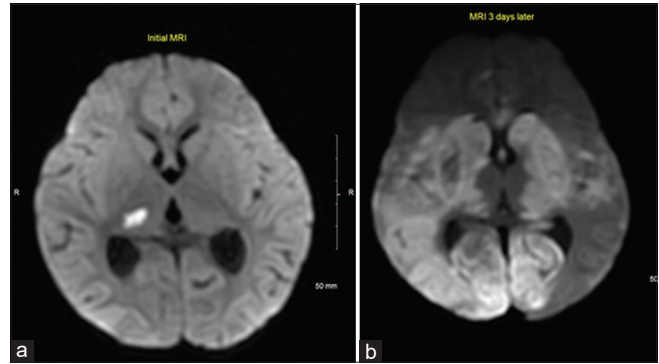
Eleven months old with fever and progressive neurological symptoms. Selected axial DWI image from the initial MRI brain (a) shows a focal punctate area of restricted diffusion, likely small infarctions involving the right thalamus. Follow-up MRI 3 days later (b) at the same level reveals marked progressively restricted diffusion of both cerebral hemispheres and bilateral deep gray nuclei (caudate, thalami, and lentiform nuclei).
